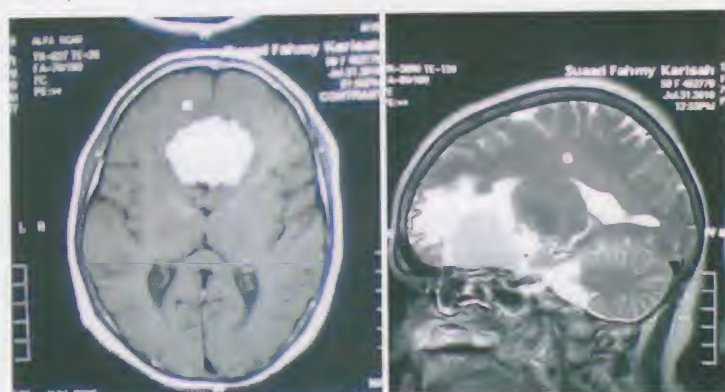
MRI axial T1 weighted image and sagittal T2 weighted image of the brain showing a brain tumor surrounded by localized brain edema which appears white on T2
